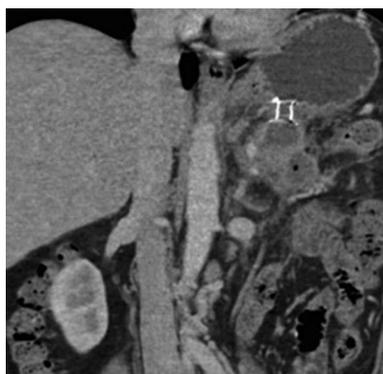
Computed tomography abdomen with visible metal stent between stomach and residual walled-off necrosis 6 wk after endoscopic ultrasonography guided insertion (initial cyst diameter 14 cm).
